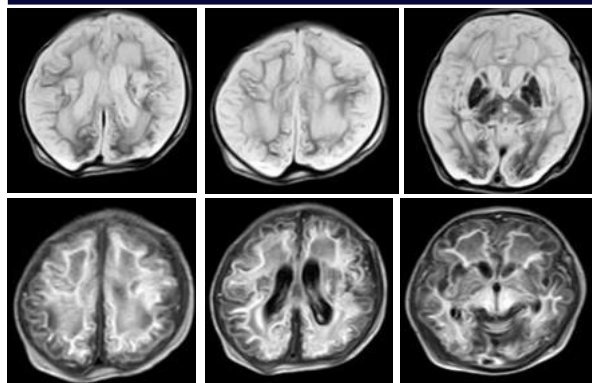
Term, low birth weight infant MRI brain showing – Symmetrical & severe paucity of white matter with associated abnormal T2 WI (a, b, c) and FLAIR (d, e, f) hyperintensities in bilateral perirolandic, centrum semiovale and periventricular regions with peritrigonal white matter predominance & gangliocapsular regions. No evidence of restricted diffusion noted on DW images in images – suggesting severe hypoxic ischemic encephalopathy.
